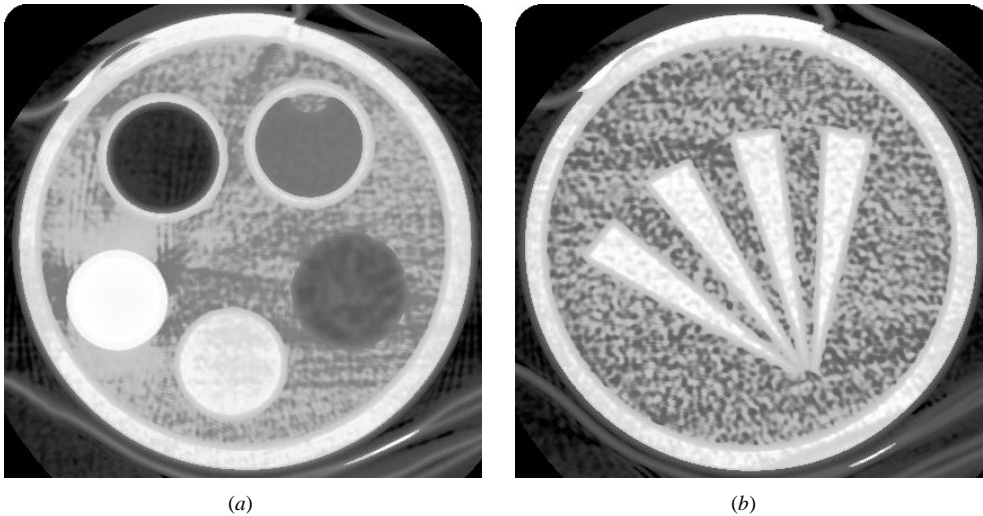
Two CT reconstructions obtained with the aid of an x-ray (GE 9800) scanner corresponding to proton reconstructions from figure 7. Contrary to proton CT reconstructions, the x-ray CT images were obtained for an optimal number of views and number of x-rays per view.
